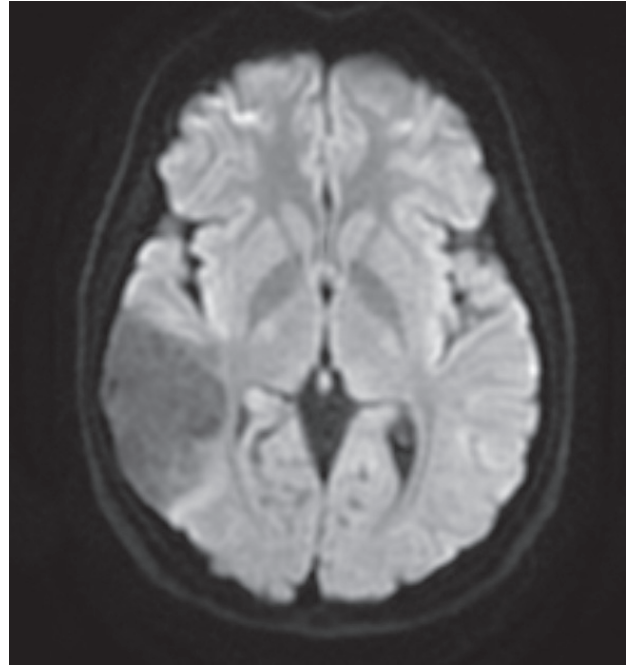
DWI Sequence of temporal region lesion showing heterogeneous diffused signals.
